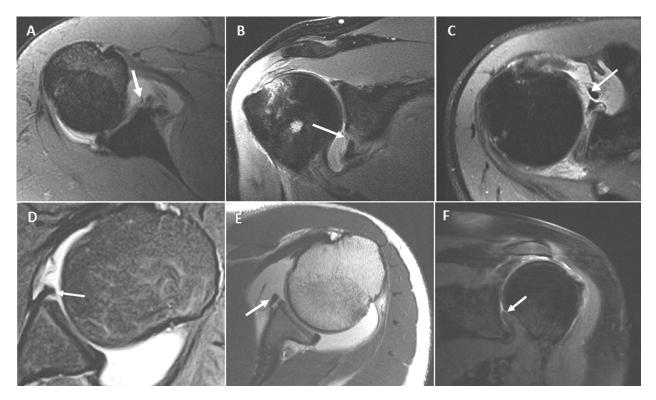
MRI of traumatic anterior injuries of the shoulder. A) Bankart lesion. B) Bony Bankart lesion. C) Perthes lesion. D) GLAD lesion. E) ALPSA lesion. F) HAGL lesion.
